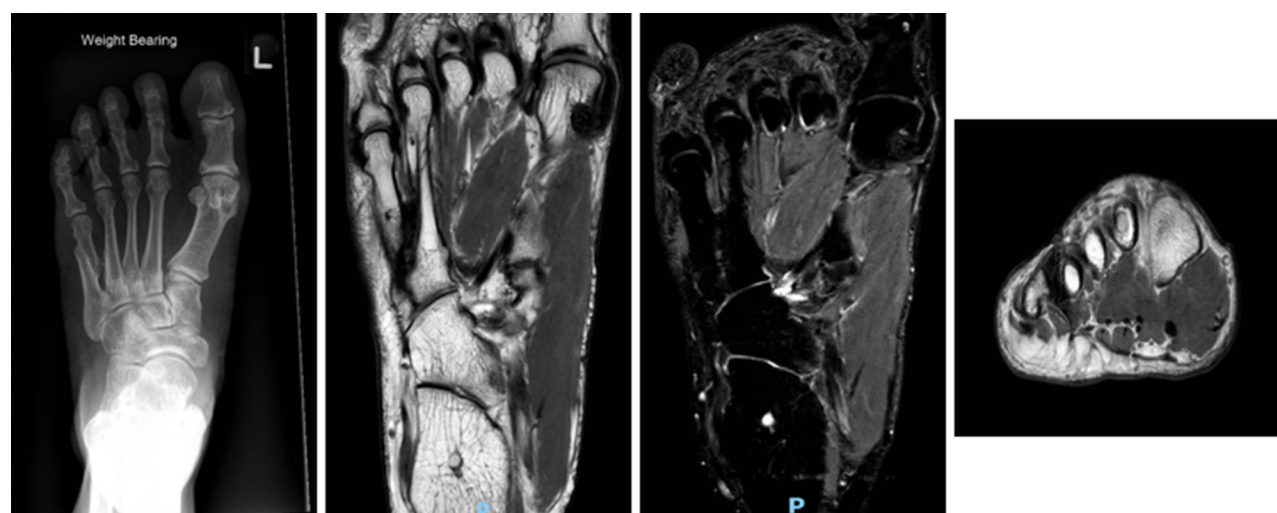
Left foot AP view X-ray and MRI Left Foot Axial and Coronal views (Left to Right) showing largely hypointense signal focus bridging the fourth and fifth metatarsal shafts representing the recurrence of synostosis
